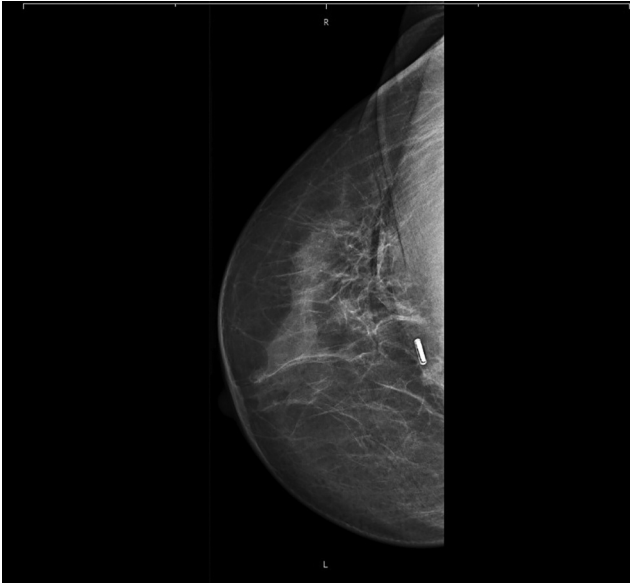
Mammography for clip localization after ultrasound-guided lesion tagging, craniocaudal projection.
